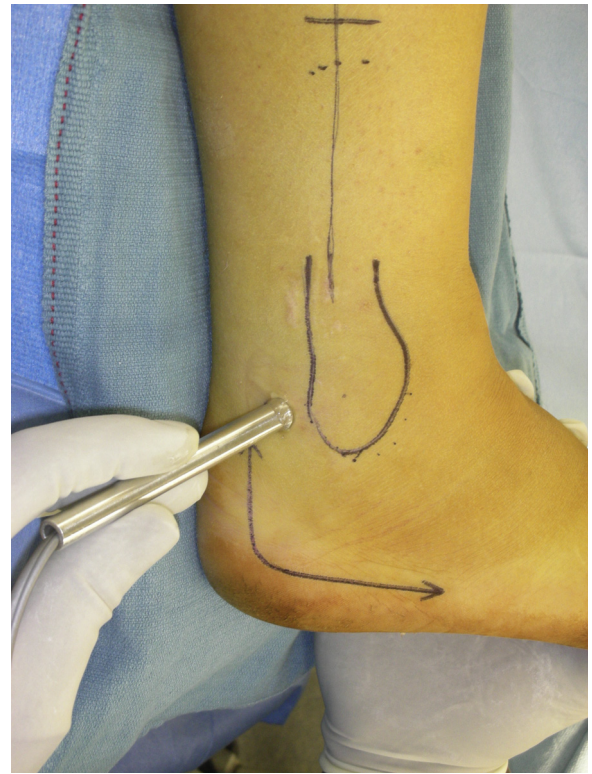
Clinical photo demonstrating use of sterile doppler to identify course of peroneal artery between intended operative incisions for distal fibula and calcaneus.
